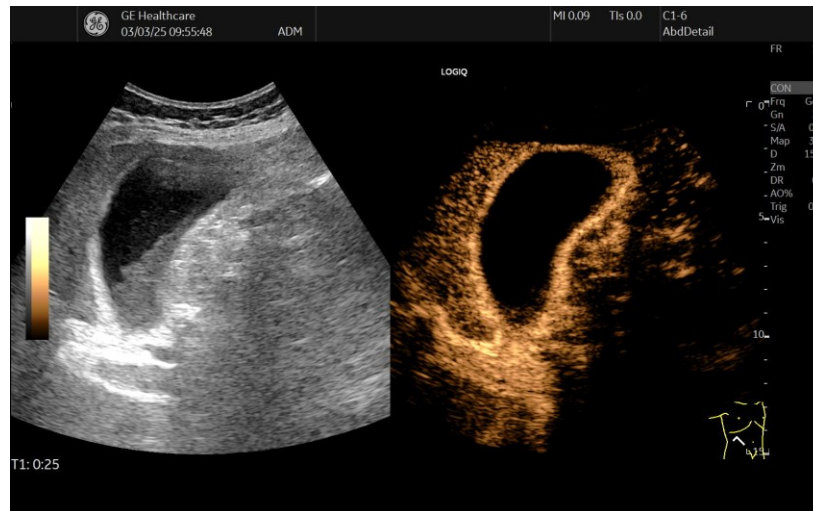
This image presents a dual-panel ultrasound examination of the gallbladder, with a conventional B-mode image on the left and a contrast-enhanced ultrasound (CEUS) image on the right. The uniform enhancement of the gallbladder wall suggests an intact vascular supply. Additionally, the anechoic lumen of the gallbladder remains non-enhancing, confirming the presence of bile and sludge.
